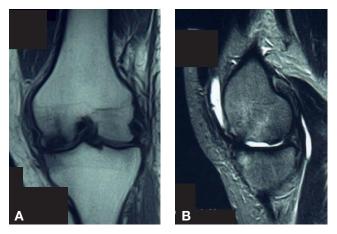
Case 1—postoperative fat-suppressed T_2 -weighted coronal (A) and sagittal (B) magnetic resonance images show osteonecrosis and collapse of the medial femoral condyle, stage IV.
